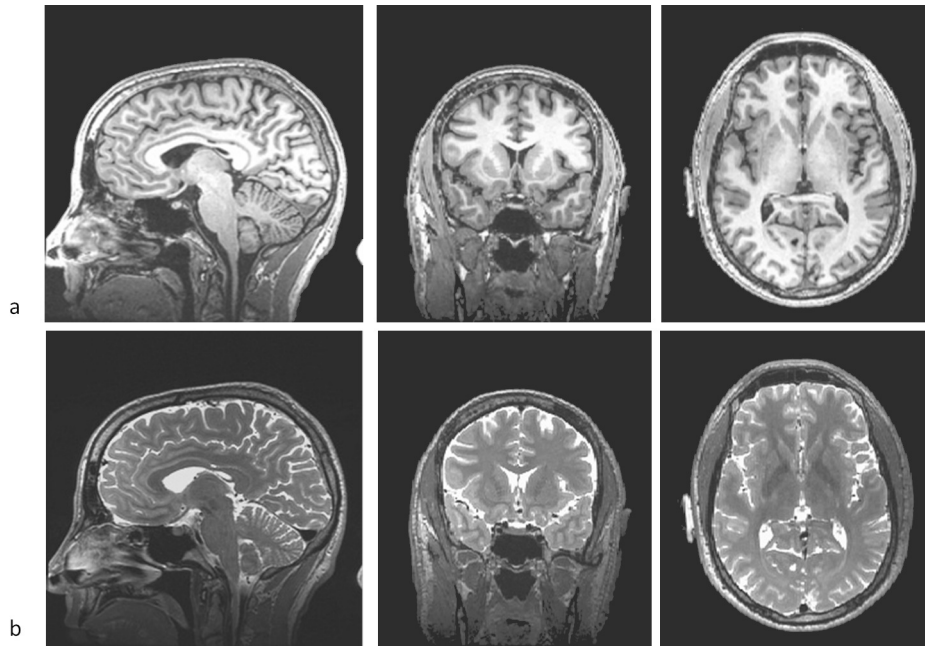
From left to right: sagittal, coronal, and horizontal planes of the brain obtained with MRI. In (a) the images were acquired with a T1-weighted sequence. The white matter has greater gray values (looks white), the gray matter appears gray, while water and CSF appear dark. Images in (b) were acquired with the T2-weighted sequence. In this type of images the white matter appears in dark gray, gray matter appears in light gray, and water and CSF appear white.
